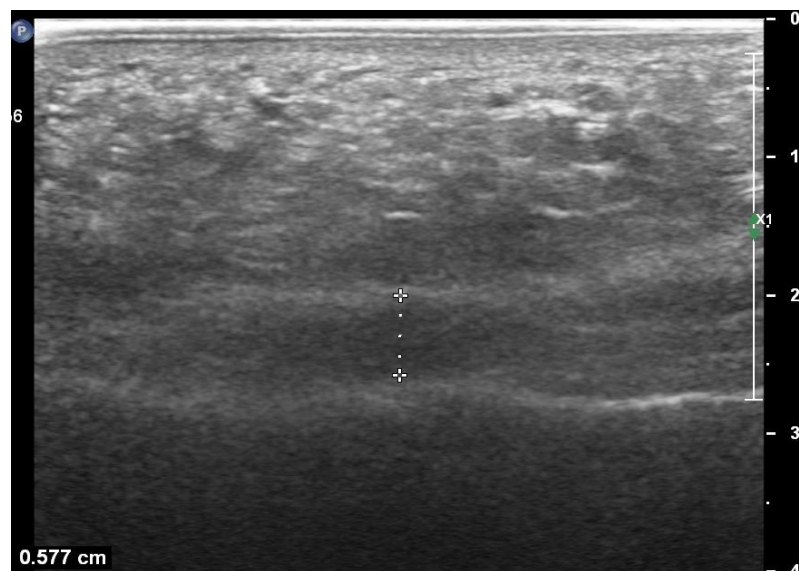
ULTRASONOGRAPHIC MEASUREMENT OF PLANTAR FASCIA THICKNESS.
